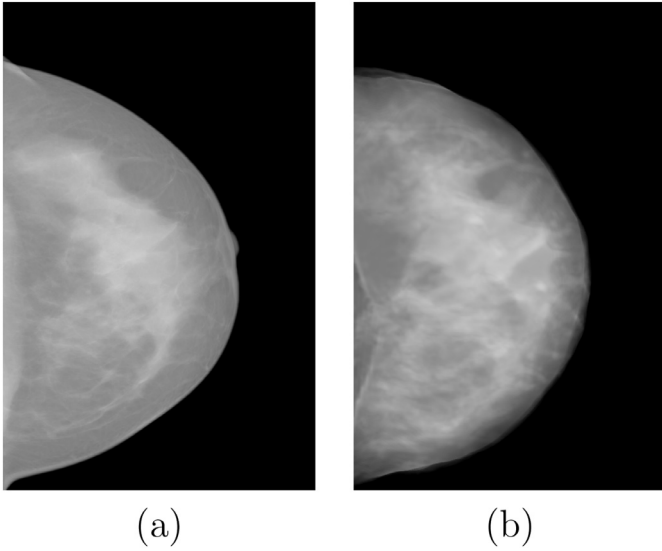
(a) Real and (b) synthetic mammogram obtained using the intensity-based registration algorithm by means of converting the MRI volume to a pseudo-CT image. In this case, the anode is composed of rhodium and the end-point energy $kVp = 31$ keV.
